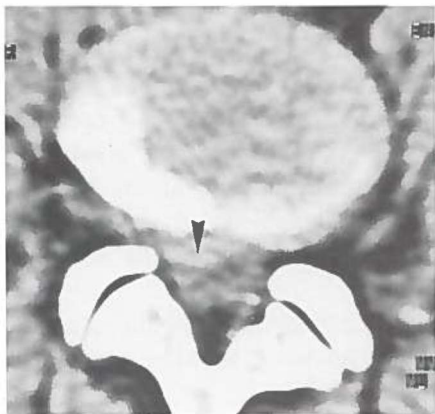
Case 3. CT scan of a right sided posterolateral herniation of disc L4-L5 (arrowhead).
